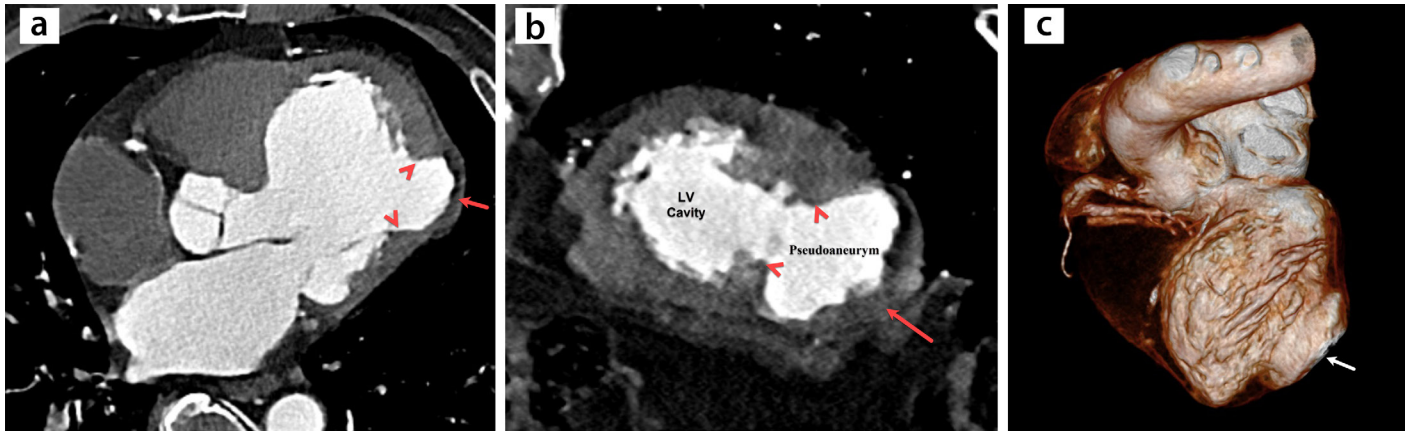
(a-c) A 68-year-old male patient presented to the emergency department with acute chest pain and underwent chest computed tomography (CT) angiography with a suspected acute aortic syndrome. The CT angiography images reveal a left ventricular pseudoaneurysm. Multiplanar reformatted CT angiography images with (a) left ventricular outflow tract view and (b) two-chamber view depicting outpouching in the left ventricle (arrows), with an abrupt transition between the healthy and thinned myocardium (arrowheads). The patient underwent surgery, and the pseudoaneurysm was repaired.
